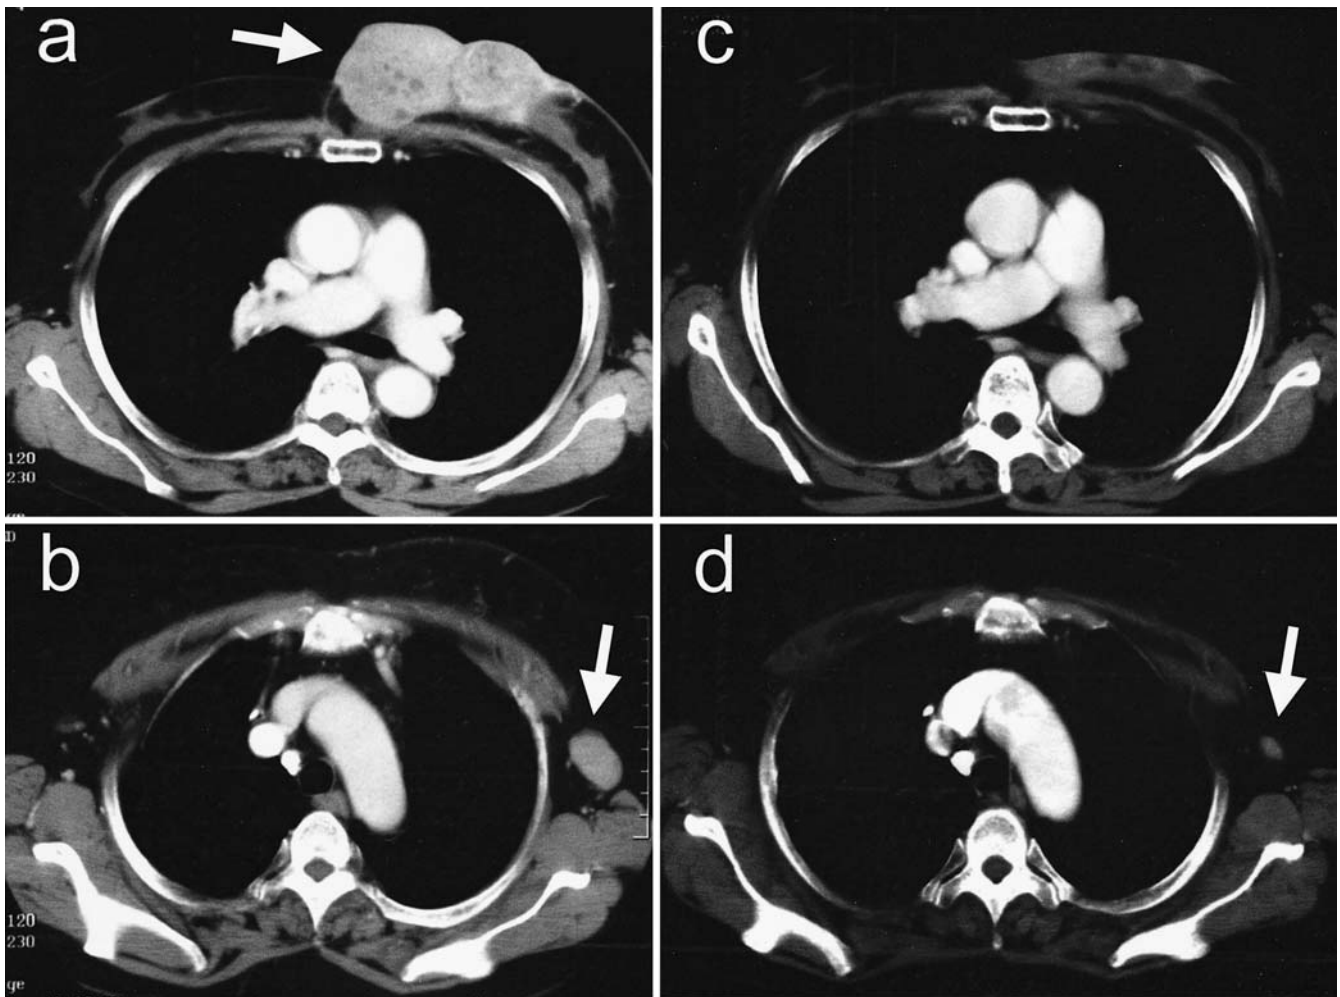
a Chest computed tomography (CT) revealed two tumors, measuring $6 \times 5.5 \times 3$ cm and $4 \times 4.5 \times 3$ cm in diameter, with variable density and suspected partial invasion to the pectoralis major muscle (*arrow*). b The left axillary lymph nodes were enlarged (*arrow*). c The
